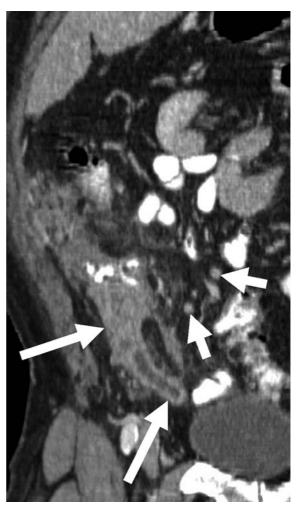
Appendiceal carcinoma pT3pN2 in a 79-year-old male, coronal reformatted contrast-enhanced CT. Thickening and cystic dilatation of the appendix with a focal soft-tissue mass at the appendiceal base (*long arrows*). Enlarged regional lymph nodes due to metastatic disease (*short arrows*)
